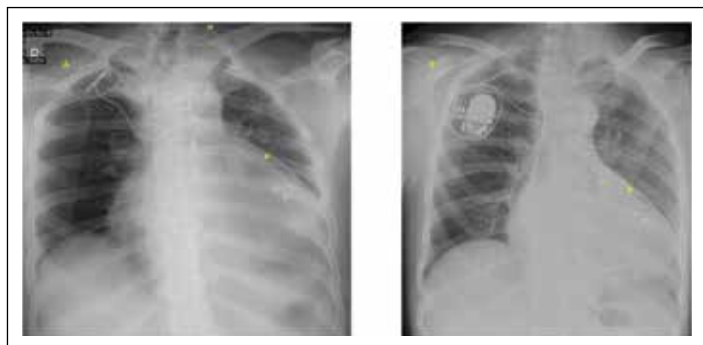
Frontal chest radiographs showing bipolar epicardial leads implanted for a CRT super-responder. This patient developed a device site infection during a pulse generator replacement. During surgical extraction of the leads, epicardial LV bipolar pacing electrodes (yellow *) were implanted, and later endocardial pacemaker leads were implanted, completing the hybrid CRT (B)
